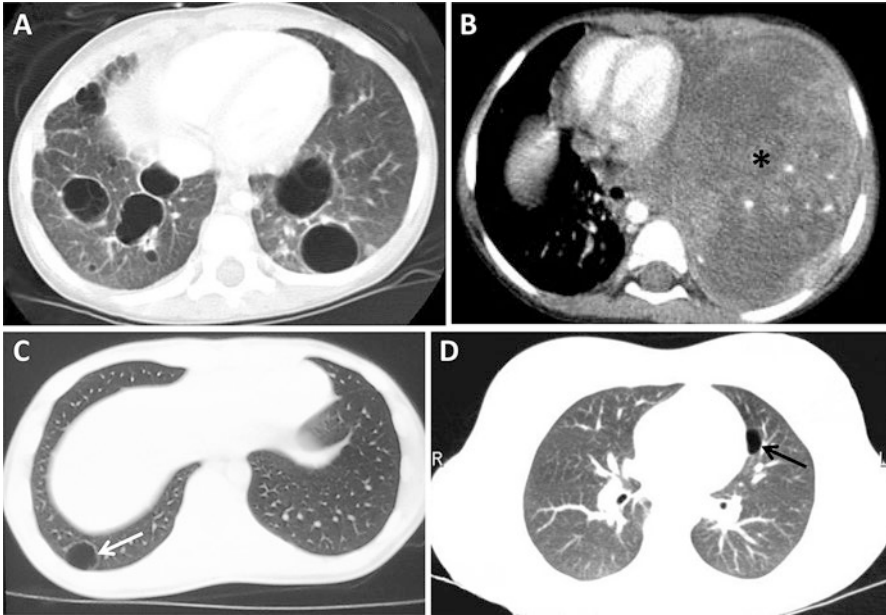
Pleuropulmonary blastoma. (a) An axial chest computed tomography (CT) image of a child with a mosaic RNase IIIb hotspot predisposing *DICER1* alteration showing numerous large and small air-filled cysts in the right and left lungs. The patient was subsequently diagnosed with bowel polyps at age 9 months, PPB Type II at 2.1 years, nasal chondromesenchymal hamartoma at 8 years, and metastases of PPB to the brain at ages 2.1 years, 3.1 years, 10.5 years, and 10.9 years. (b) An axial chest CT image with black asterisk indicating Type III PPB filling the hemithorax. (c and d) Axial chest CT images in which small arrows identify occult air-filled lung cyst in variant carriers, which likely represent Type Ir PPB. Patient C developed an esophageal juvenile hamartomatous polyp and multinodular goiter and has a family history of *DICER1* syndrome. Patient D was diagnosed with multinodular goiter at age 12 years and had an older sister with *DICER1* syndrome, which occasioned chest imaging. (Images courtesy of Barbara Pasini, M.D. [C] and the patient [D])
